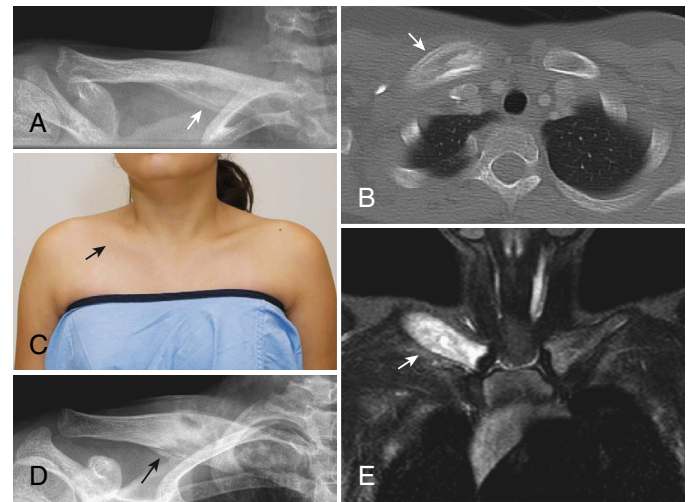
Clavicular involvement in chronic recurrent multifocal osteomyelitis. Adolescent female with unilateral clavicular involvement. A, Plain radiograph of the right clavicle at presentation reveals widening of the medial two-thirds, with associated periosteal reaction. B, Corresponding CT scan of the right clavicle demonstrates expansion of the medial right clavicle with areas of increased sclerosis accompanied by a surrounding periosteal reaction (arrow). C, Flare of disease 18 months later showing further clavicular enlargement (clinical photo). D, Plain radiograph of the right clavicle at that time demonstrates marked interval sclerosis and thickening. E, MRI at the same time shows increased signal intensity on fat-suppressed contrast-enhanced T1-weighted images of the right medial clavicle consistent with continued inflammation. (Images courtesy Dr. Paul Babyn, University of Saskatchewan and Saskatchewan Health Authority, Saskatchewan, Canada.)
